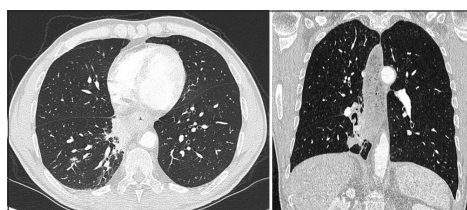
Computed tomography thorax postantibiotic therapy, axial and coronal slices
